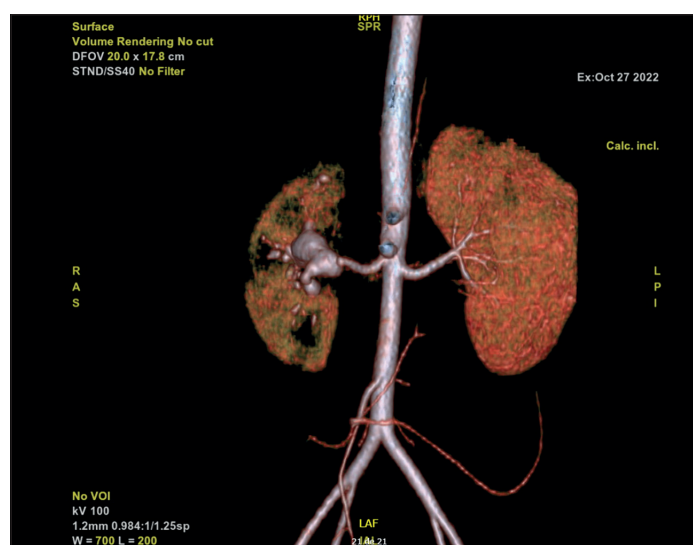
3D reconstruction of abdominal angio-CT with contrast. Fusiform aneurysm of the right renal artery.
